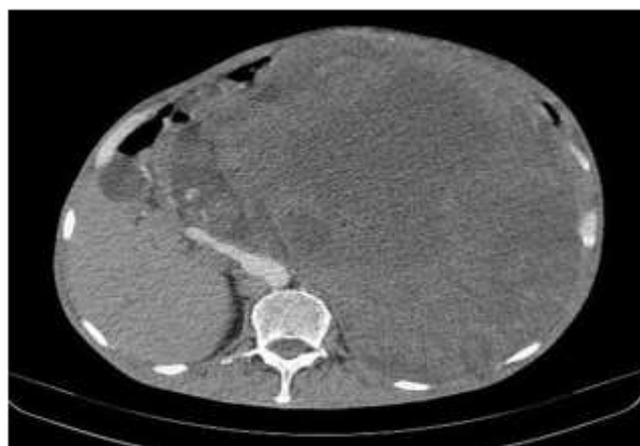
Axial contrast-enhanced CT scan of the abdomen showing a large mass of the left flank with locoregional infiltration and mass effect on adjacent structures.
